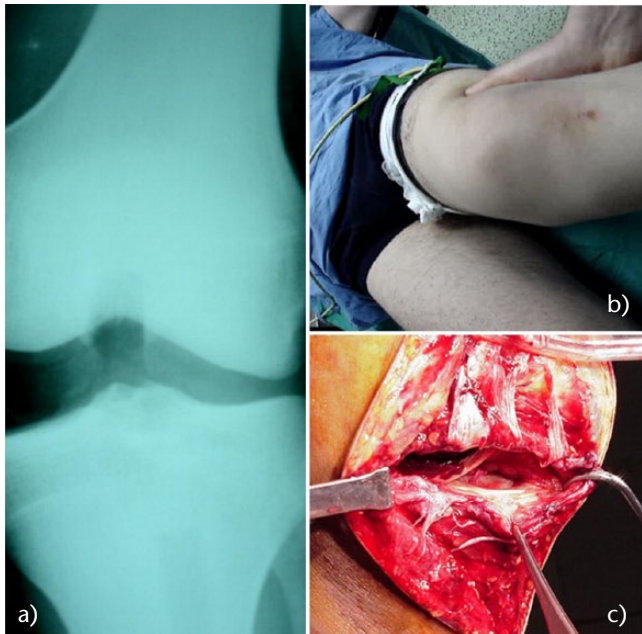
A patient with antero-medial rotatory instability. a) Valgus stress radiographs; b) Manual valgus stress testing; c) Severe damage to the medial structures seen during surgery.
